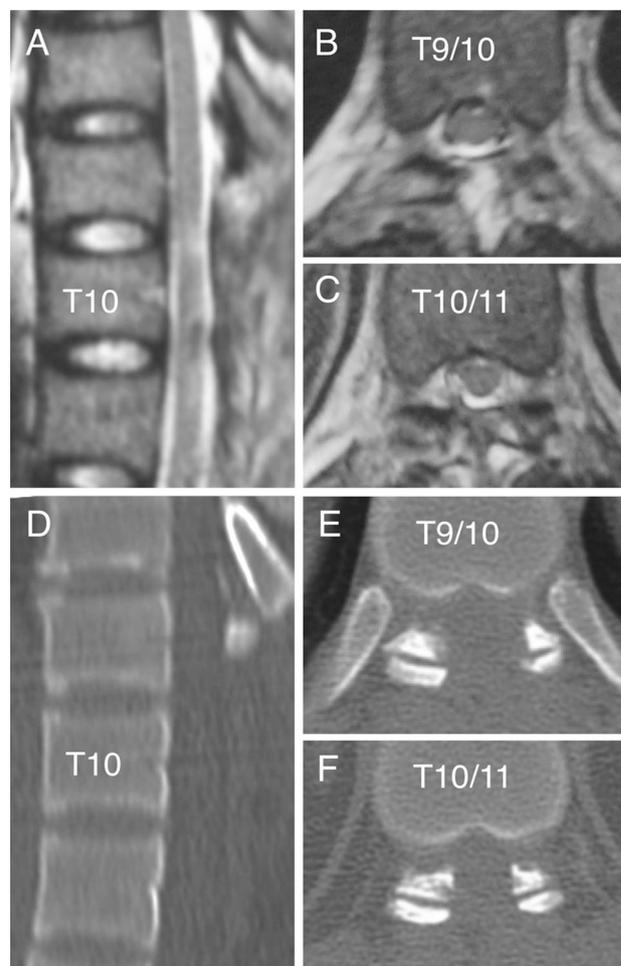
Case 1. MR images and CT scans obtained after the first operation. Sagittal (a) and axial (b, c) T2-weighted images show the presence of cerebrospinal fluid around the spinal cord at the T9–10 and T10–11 levels, and the spinal cord was sufficiently decompressed. Sagittal reconstruction (d) and axial (e, f) CT scans show the OLF in the spinal canal, and the medial part of the facet joint was adequately resected at the T9–10 and T10–11 levels
